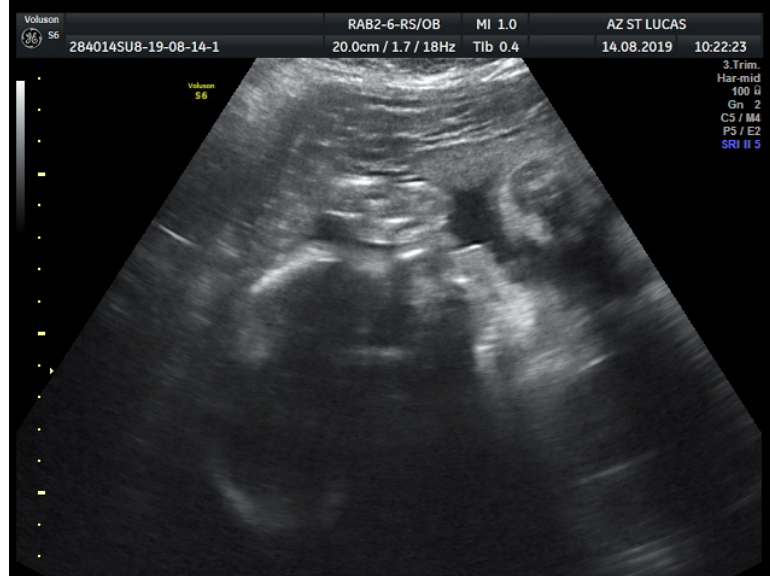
An example of an image obtained by ultrasound, an "echo" of my lovely daughter Esther Caribé with 32 weeks of life.
